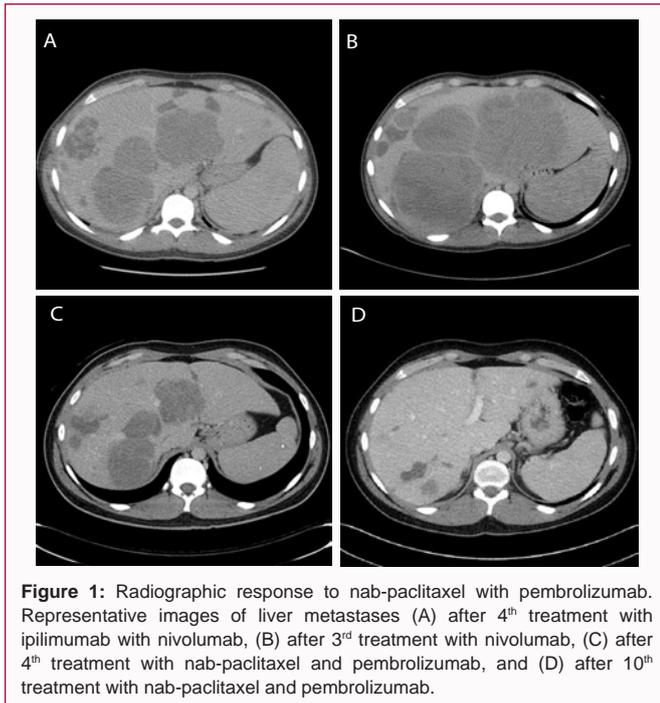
Radiographic response to nab-paclitaxel with pembrolizumab. Representative images of liver metastases (A) after 4th treatment with ipilimumab with nivolumab, (B) after 3rd treatment with nivolumab, (C) after 4th treatment with nab-paclitaxel and pembrolizumab, and (D) after 10th treatment with nab-paclitaxel and pembrolizumab.
